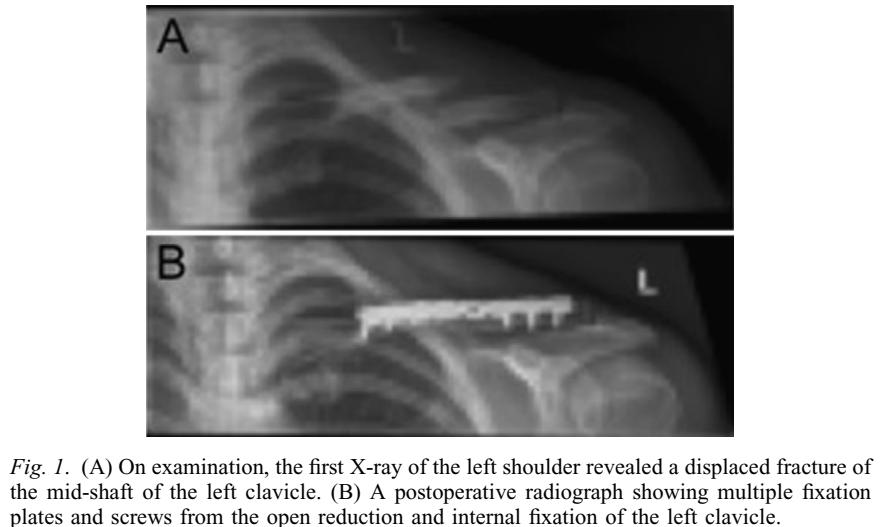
(A) On examination, the first X-ray of the left shoulder revealed a displaced fracture of the mid-shaft of the left clavicle. (B) A postoperative radiograph showing multiple fixation plates and screws from the open reduction and internal fixation of the left clavicle.
